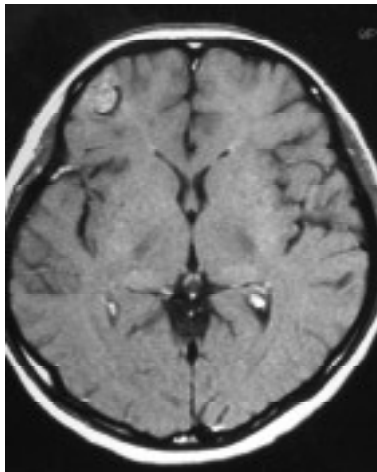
Previous axial enhanced T1-weighted MR image of same patient as Figs. 1-3b shows no significant enhancement.
